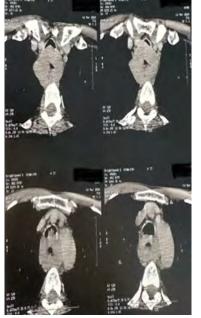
CT chest angiography
